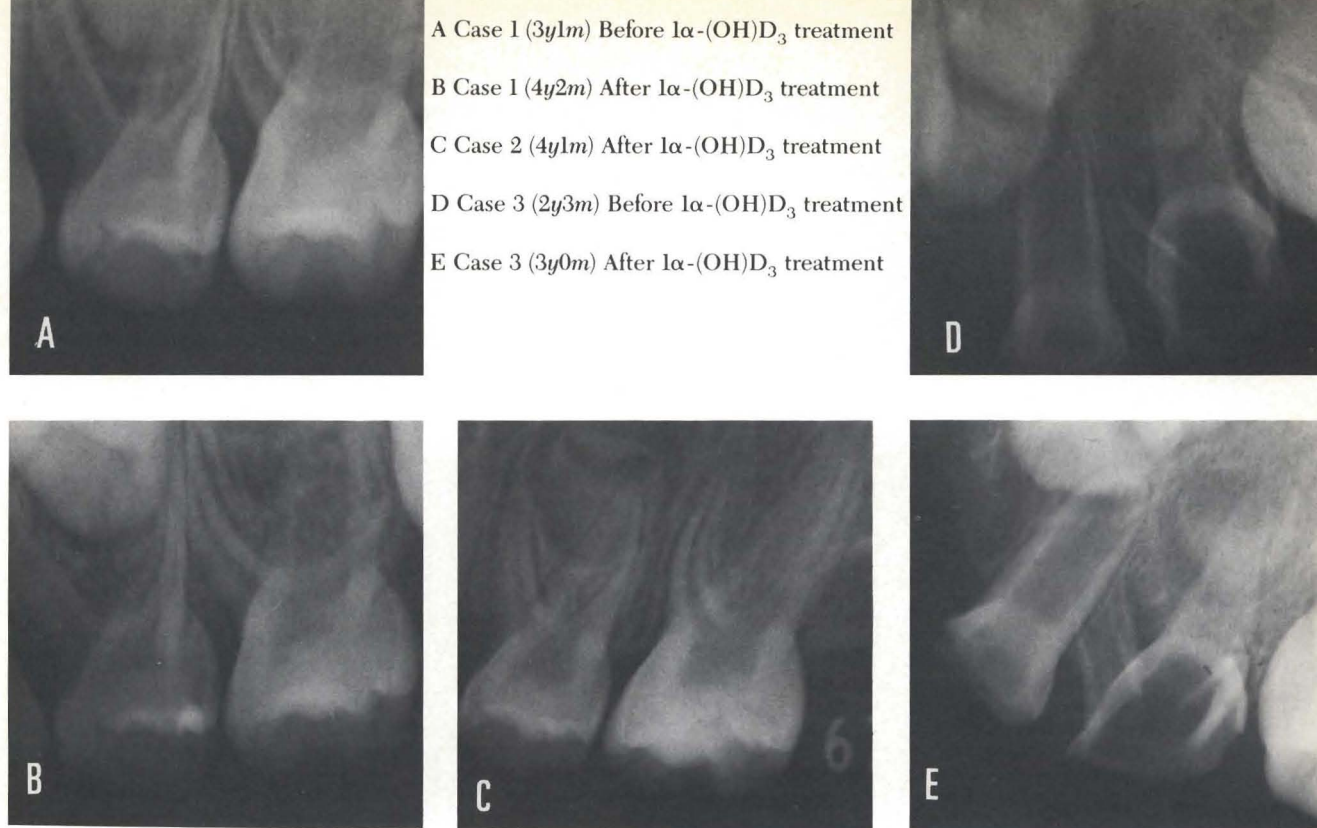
Radiographic findings of upper left primary molars.
